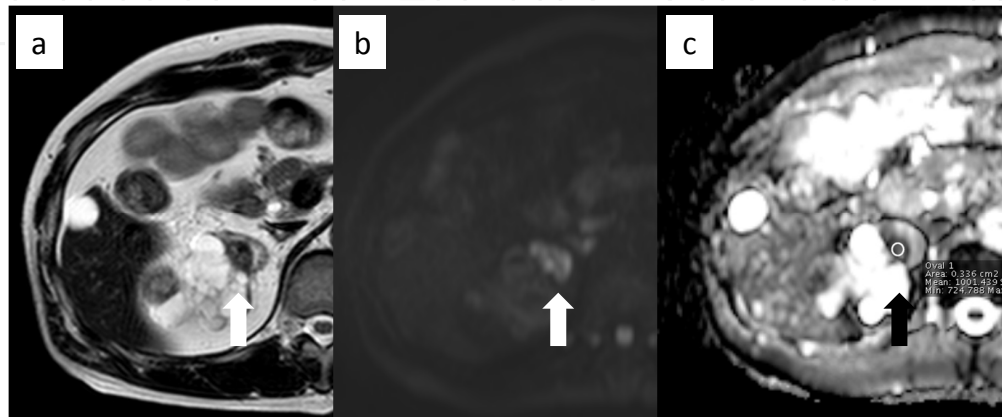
MRI images of a 71-year-old man with ACD-associated RCC. a: Axial T2WI shows a heterogenous signal intensity mass (arrow). b: DWI shows heterogenous high signal intensity mass (arrow). c: ADC map demonstrates the tumor (arrow) with ADC value of $1.00 \times 10^{-3} \text{ mm}^2/\text{s}$.
